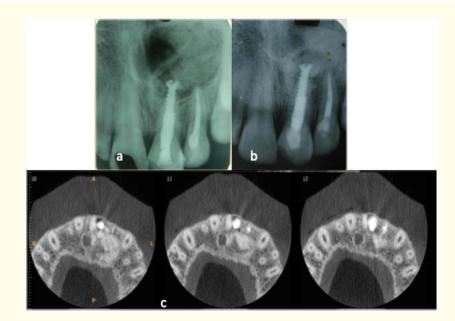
(a) IOPA radiograph after one week of stabilizer placement showing obturation and post endodontic restoration, (b) 5 year follow up IOPA radiograph, (c) 5 year follow up CBCT showing formation of labial cortical plate.
